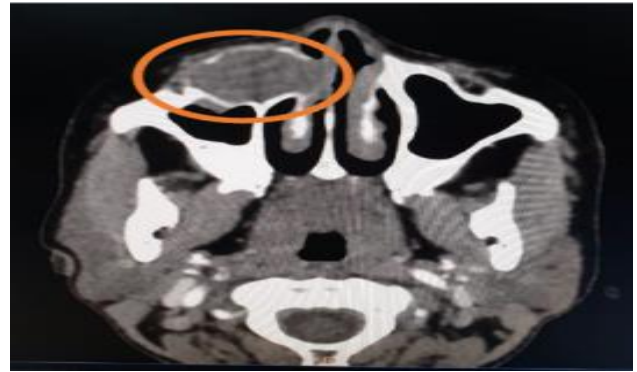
Mass seen in axial section of CT PNS.
